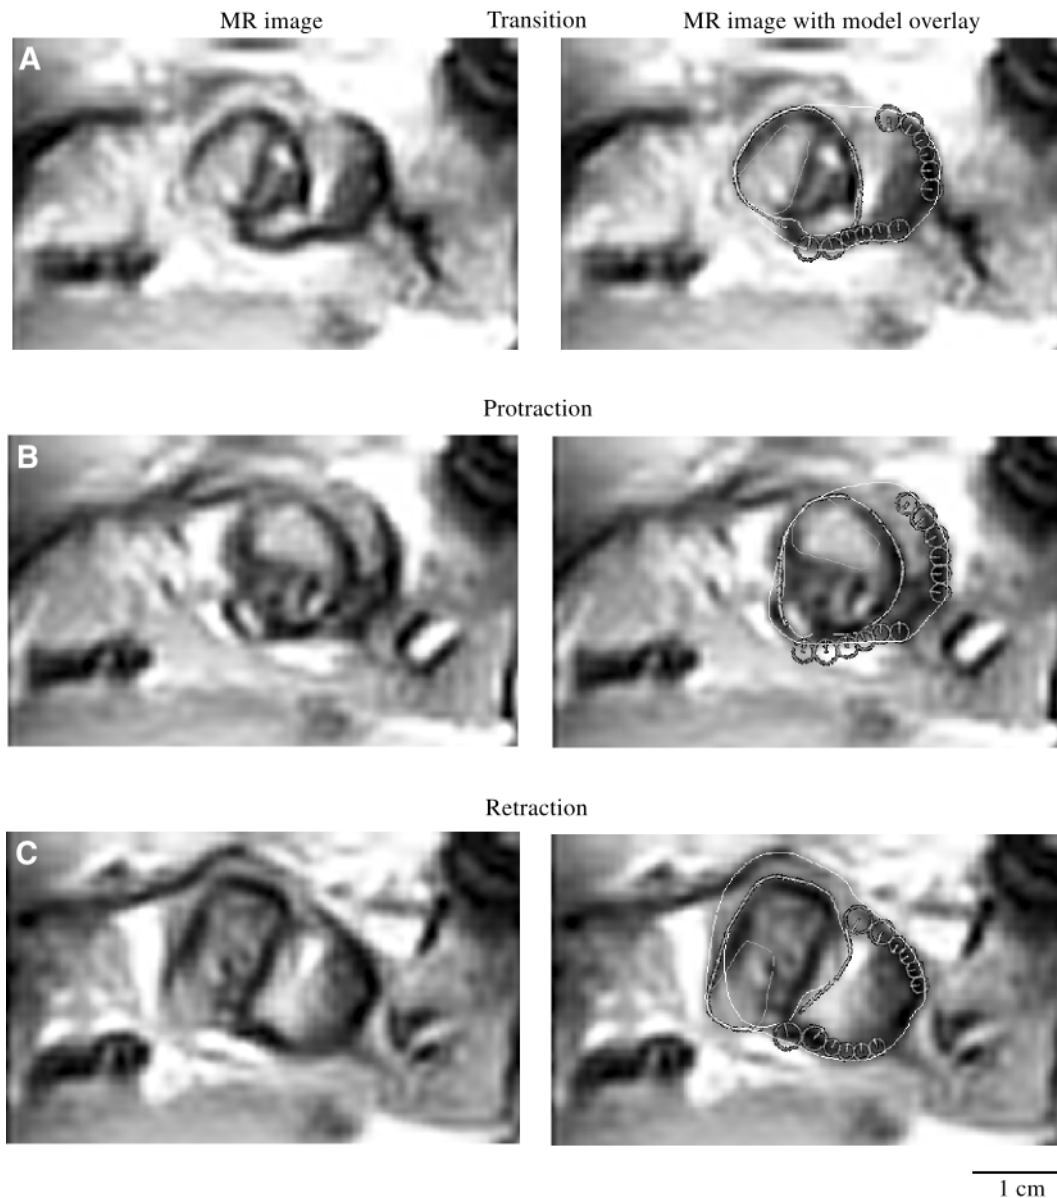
Comparison of mid-sagittal magnetic resonance images (MRIs) (left) and superimposed mid-sagittal outputs (right) from the model. The frames shown are from sequence 7732-S3, frame 17 (A), sequence 7732-S3, frame 24 (B), and sequence 7732-S3, frame 35 (C). The outline of the odontophore, the outline of the radular stalk and the overall outline of the buccal mass were initially extracted from the MRIs shown on the left. The dorsal and ventral cross sections of the model I3 rings were placed by the model.
